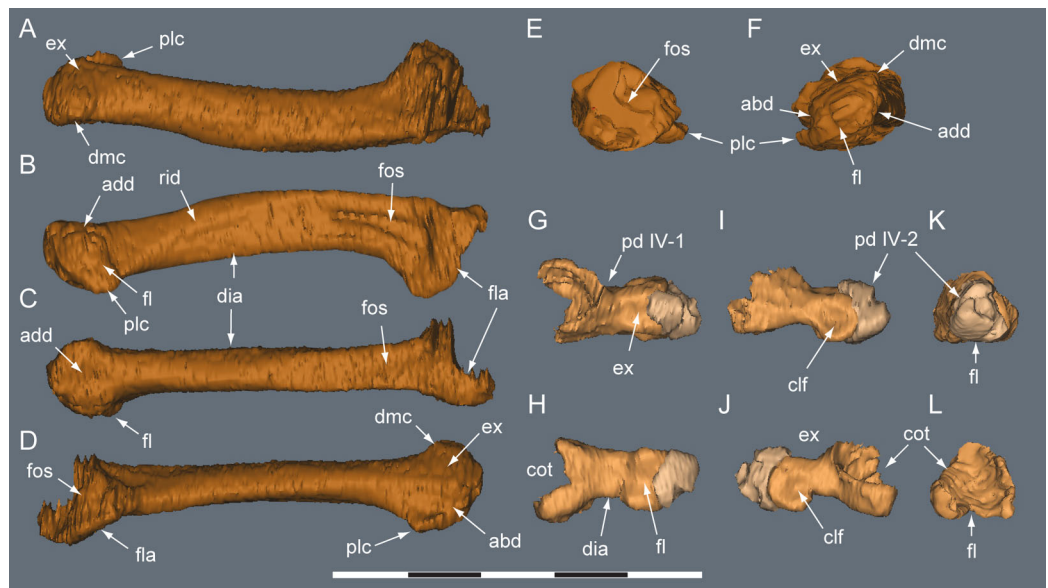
Diluvicursor pickeringi* gen. et sp. nov. holotype (NMV P221080), CT model of right pedal digit IV. A–F, mt IV in: (A) dorsal; (B) plantar; (C) medial; (D) lateral; (E) proximal; and (F) distal views. G–L, pd IV-1 and pd IV-2 in: (G) dorsal; (H) plantar; (I) lateral; (J) medial; (K) distal; and (L) proximal views. Abbreviations: abd, abductor surface/groove; add, adductor surface/groove; clf, collateral ligament fossa; cot, cotyle; dia, diaphysis; dmc, dorsomedial condyle; ex, extensor groove or surface; fl, flexor groove or surface; fla, flange; fos, fossa; pd #, pedal digit number and phalanx position; plc, plantolateral condyle; rid, ridge. Scale bar equals 50 mm. [Full-size !\[\]\(5fd6ef84f97f42d7f8b34275f1b65312_img.jpg\) DOI: 10.7717/peerj.4113/fig-26](https://doi.org/10.7717/peerj.4113/fig-26)
